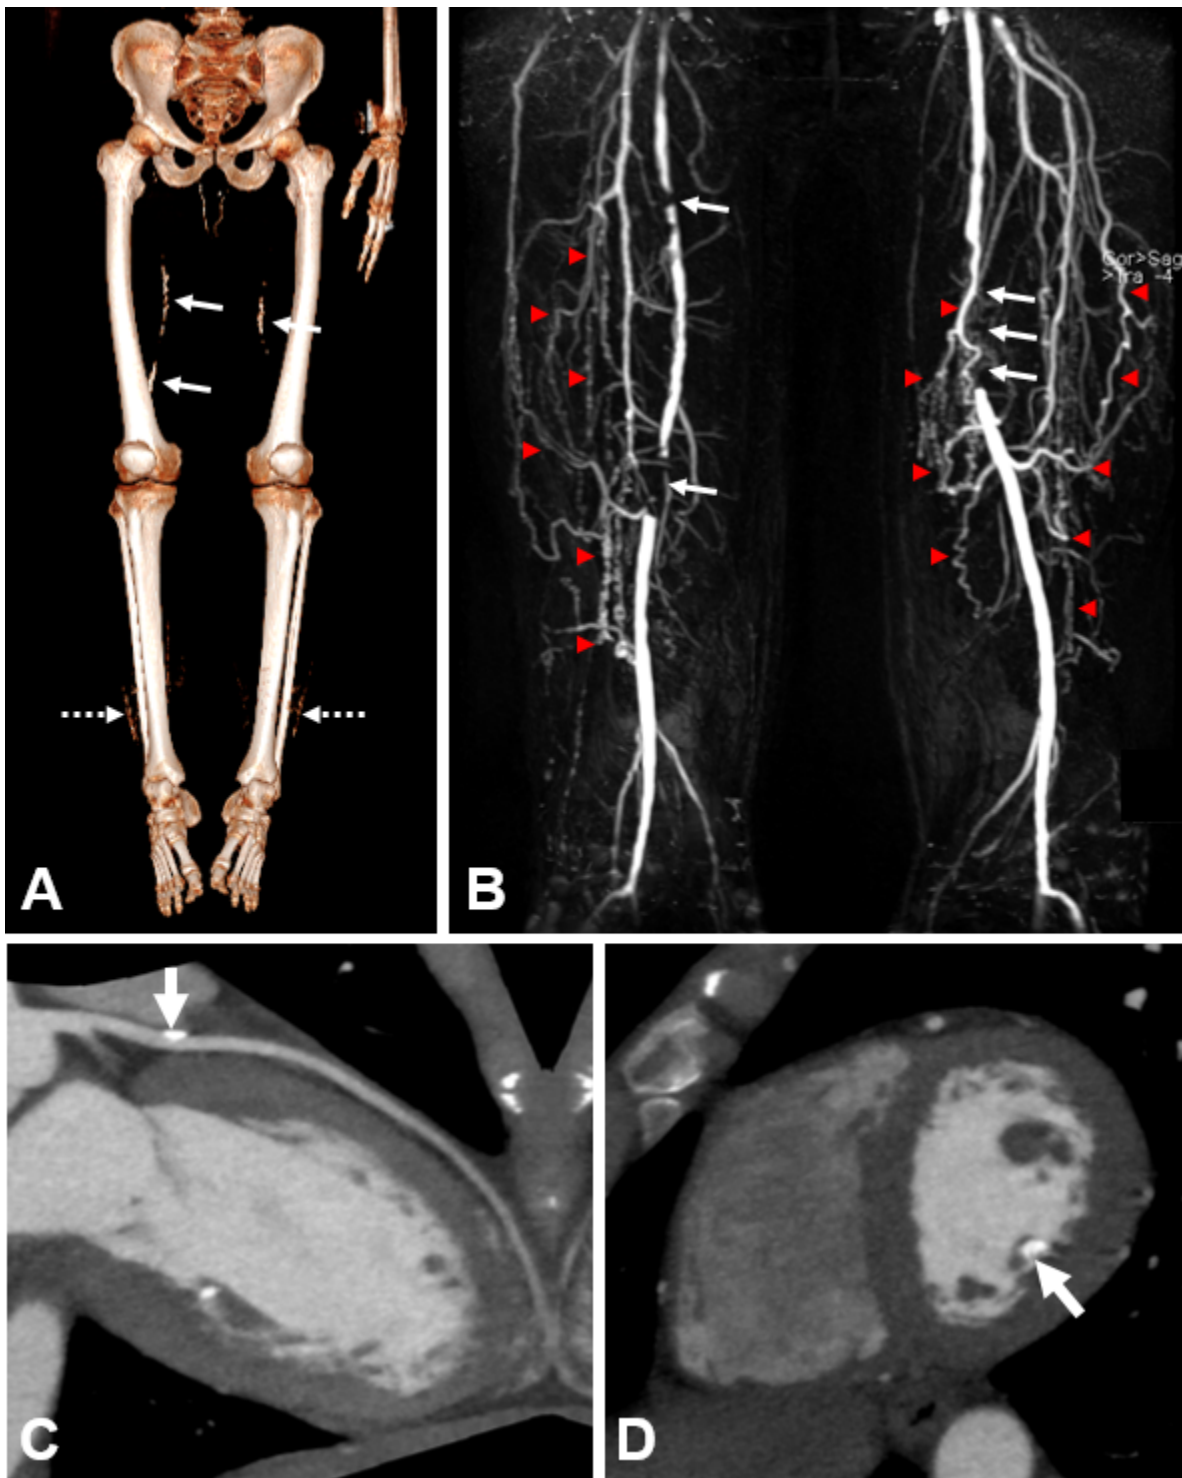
A. CT 3D reconstruction in an adult with HFTC demonstrating bilateral vascular calcifications in superficial femoral arteries (solid arrows) and multifocal sheet-like calcification of the subcutaneous tissues at the level of the distal tibiae and fibulae (dashed arrows)
